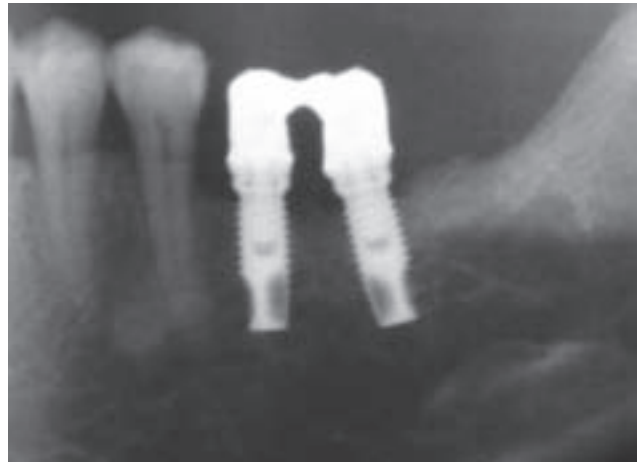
Orthopantomogram showing implants 36 and 37 at the time of temporary crown positioning, 1 month after membrane removal. A little bone loss in the vertical dimension is the consequence of the premature membrane exposure.
